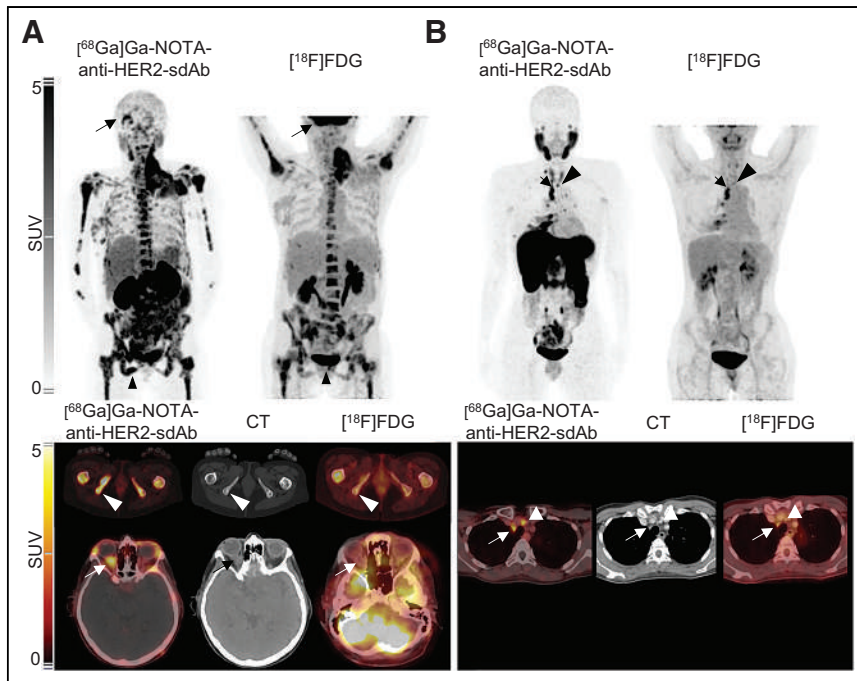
For patient 6 (A) and patient 3 (B), [^{18}F]FDG (top right) and [^{68}Ga]Ga-NOTA-anti-HER2-sdAb (top left) maximum-intensity projection PET images and additional axial CT (bottom center) and PET/CT (bottom left and right) images. Patient 6 was HER2-negative patient with bone metastases, with mass in neck and recent right exophthalmia. In [^{68}Ga]Ga-NOTA-anti-HER2-sdAb image, uptake in these regions was confirmed, but metastatic lesions in os ischium (arrowhead) and right orbita (arrow) were better identified than on [^{18}F]FDG. Patient 3 was HER2-positive patient with [^{18}F]FDG-avid lymph nodes in mediastinum. Extent of disease to cervical lymph node (arrow) was better delineated on [^{68}Ga]Ga-NOTA-anti-HER2-sdAb PET.
